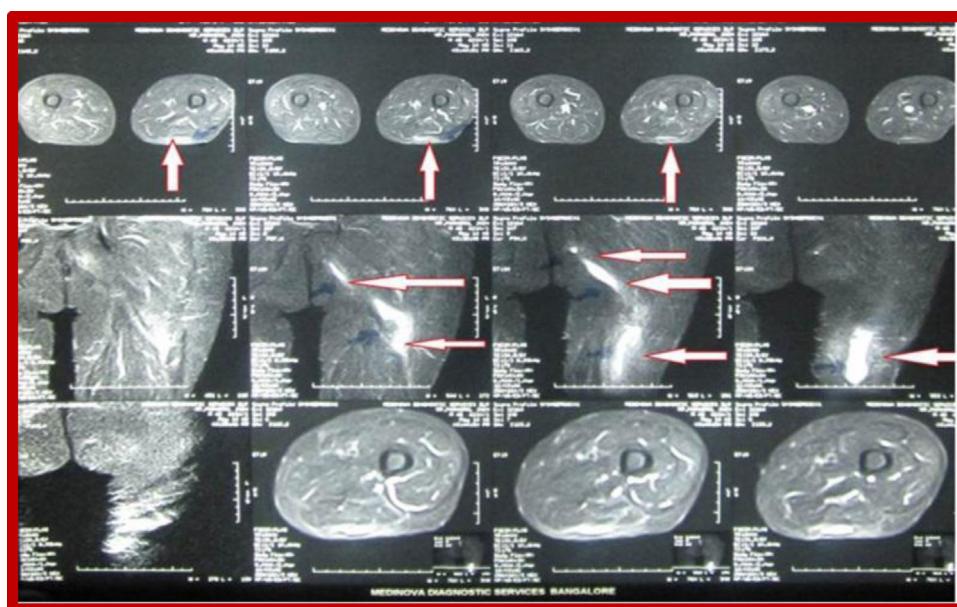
MRI study revealing extension toward left lower limb.
